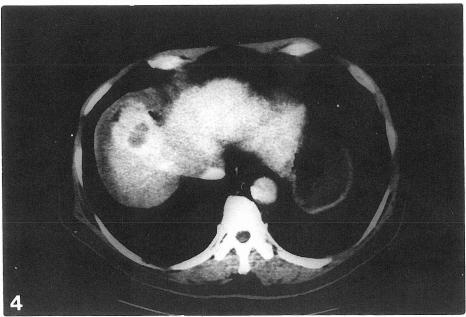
Case 2: One protruding liver tumor close to the diaphragm was indicated by CT.
